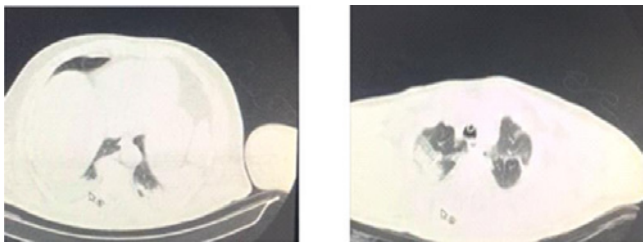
Computed tomography before treatment.
